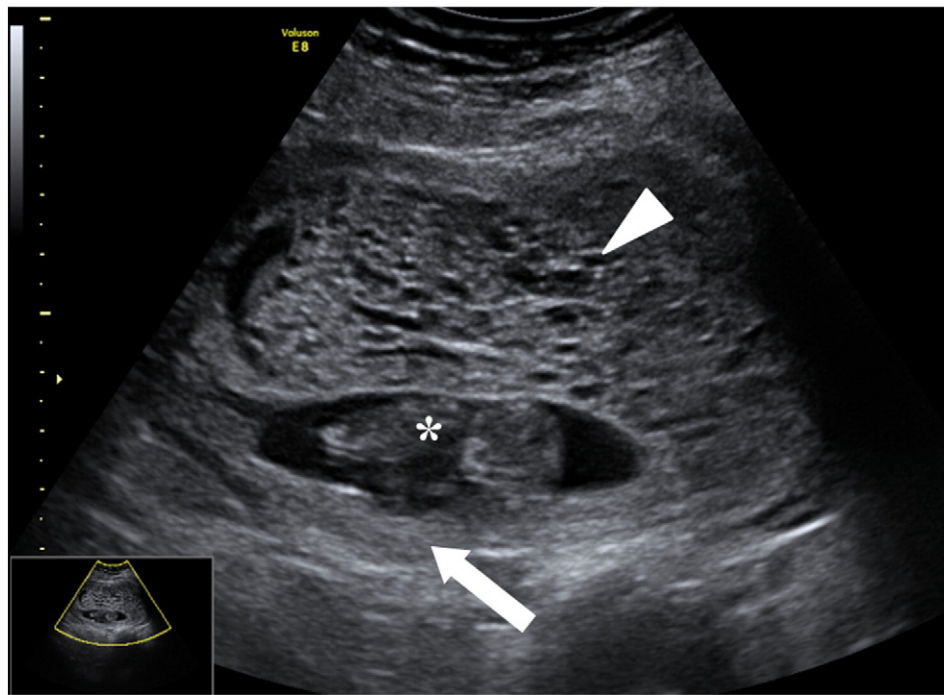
Transabdominal ultrasound. Transabdominal ultrasound showing a live normal fetus (asterisk) and placenta (arrow), consistent with the gestational age, under a large mass resembling molar placenta located at the anterior uterine wall (arrow head).
